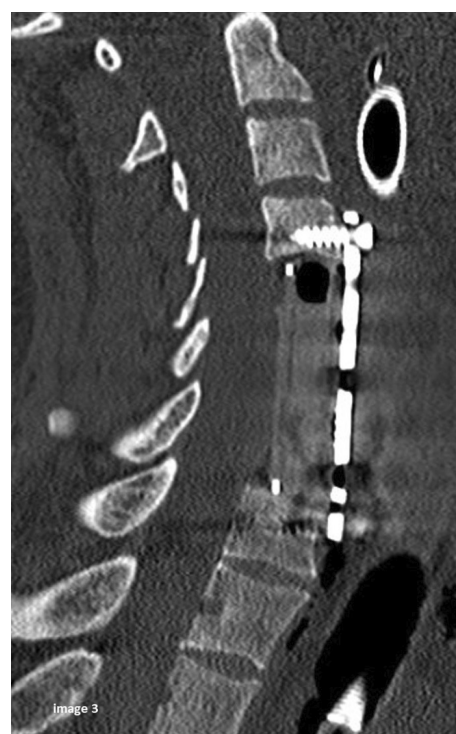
Intraoperative CT scan with bone window demonstrating C4, C5, C6 corpectomy, with the insertion of an Expandable PEEK cage.
